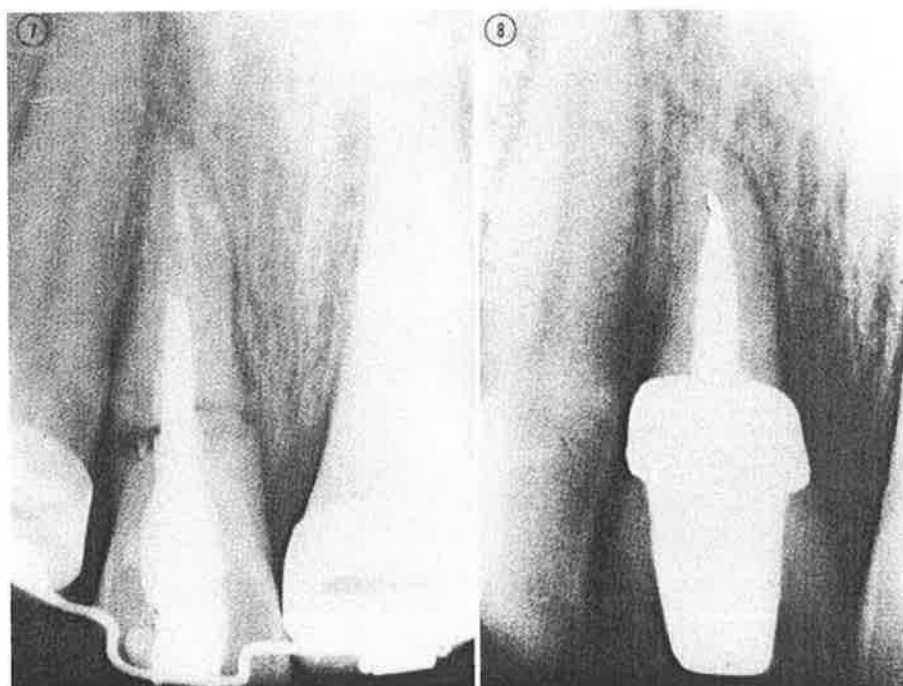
Case 1. Radiograph showing the tooth after it had been moved 4 mm. by controlled orthodontic treatment. Note the slanting of alveolar bone which has accompanied the tooth in its incisal movement (Method 1C).
